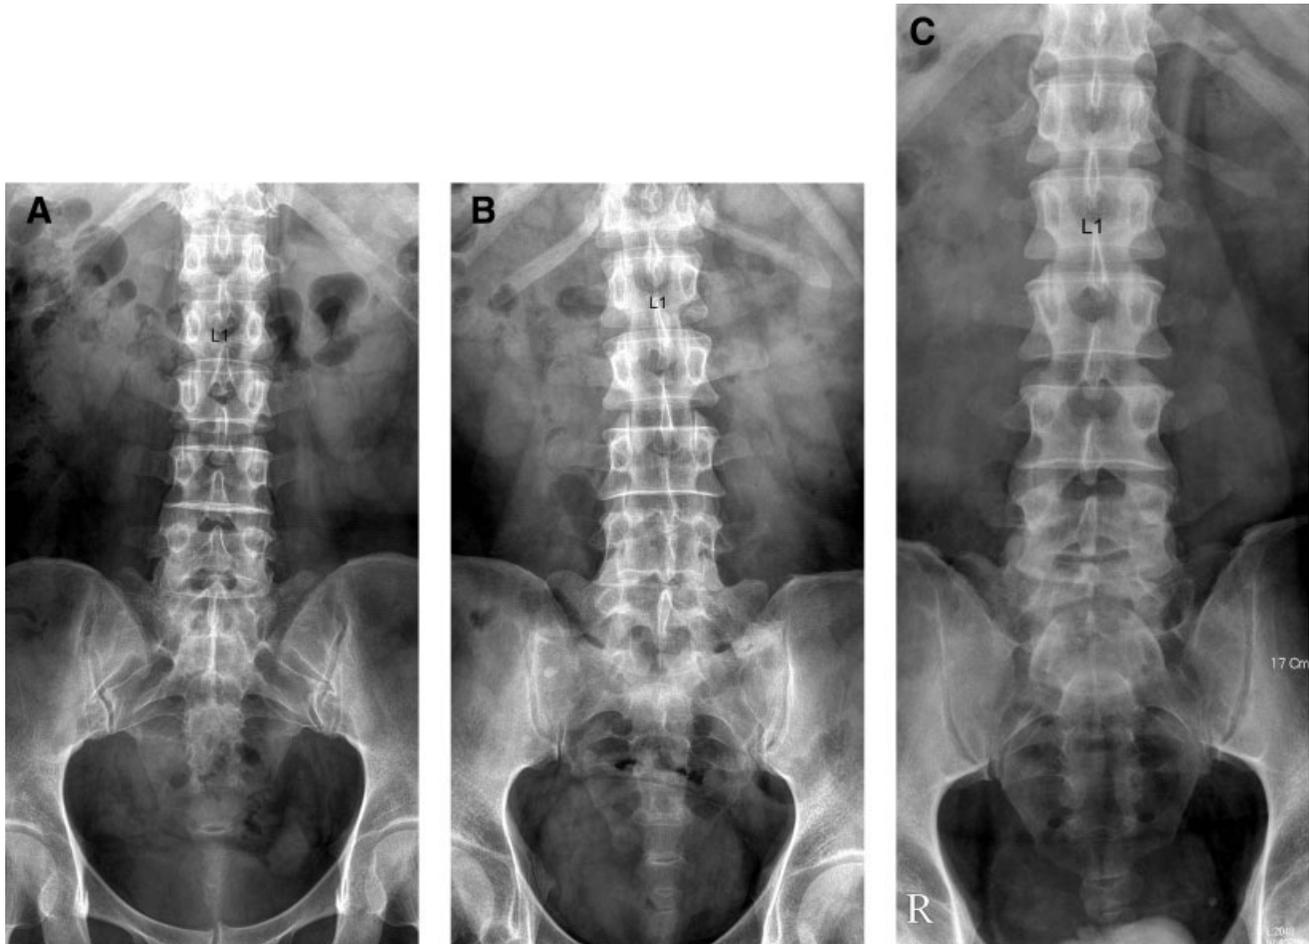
Type of sacralization. A: Complete sacralization. Lumbar AP radiograph shows the complete fusion of the L5 transverse process with the S1 vertebra. The absence of a 12th rib is also apparent. B: Incomplete sacralization. Lumbar AP radiograph reveals bilateral
